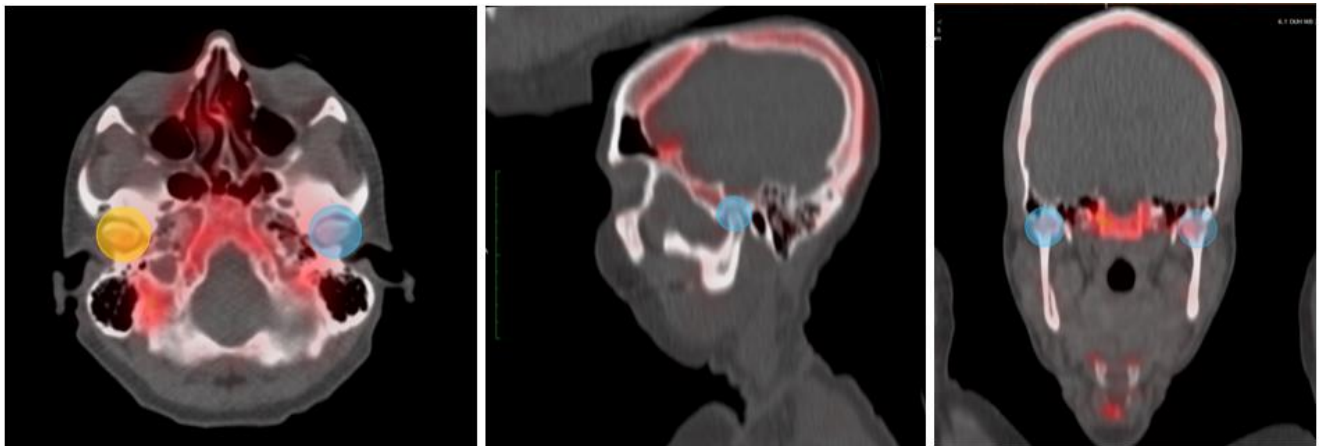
ROI including the osseous compartment of TMJ in transverse, sagittal and coronal slice of a fused PET/CT scan.
